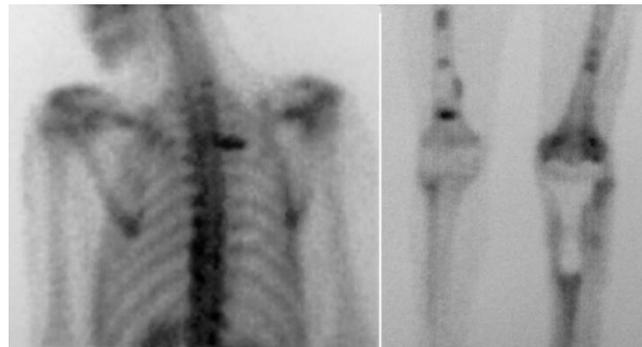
Bone scintigraphy showing hypercaptation, visible in thorax and in the right distal third of the femur.
